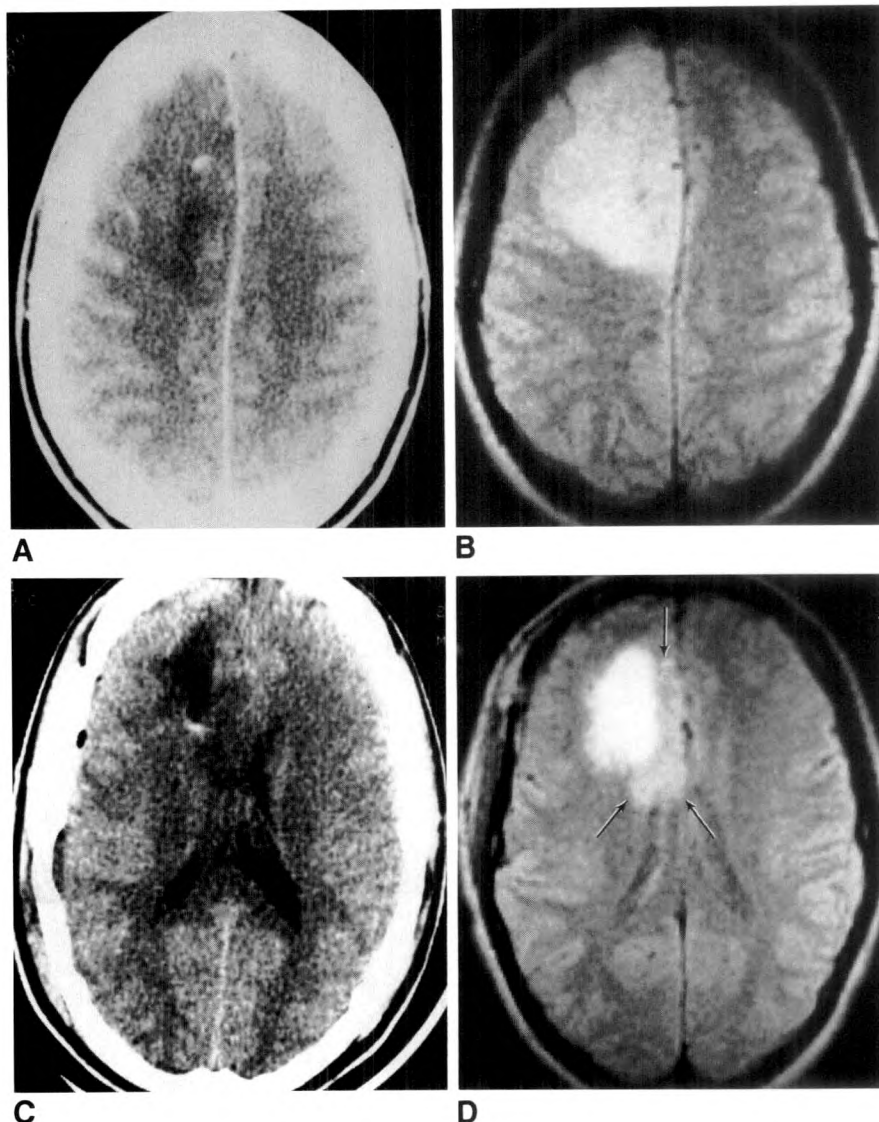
A, CT of oligodendroglioma. Poor definition of lateral border of lesion.
